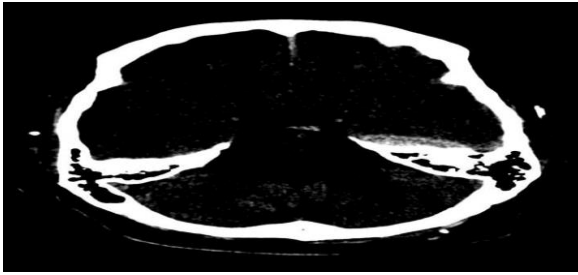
An axial CT of the brain shows a hyper density rear to the temporal lobe and anterior to petrous part of the temporal bone on the left side using the bone window.
